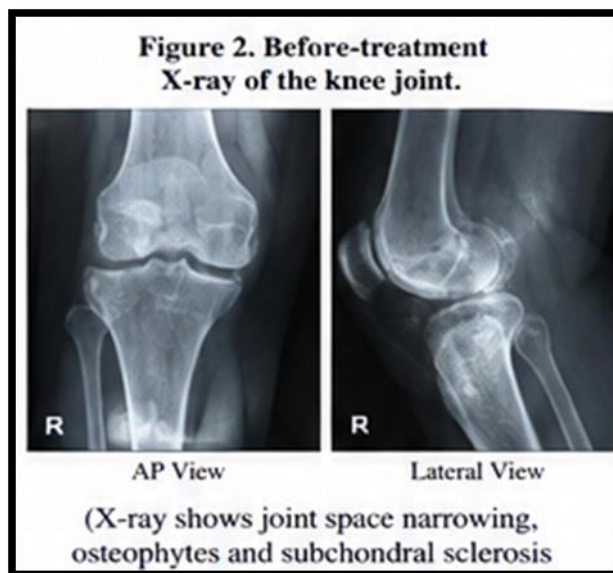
Before-treatment radiograph of the knee joint.
